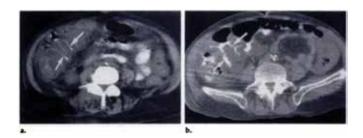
CT of Pseudomembranous colitis Marked thickening of the right side of the colon with tracking of contrast material (arrows) between the thickened folds. Thickening of pericolonic tissues is perceived. (b) Extensive inflammation of the right side of the colon with layers of contrast material between inflamed muccus folds (arrows). (FISHMAN, 1991)¹⁹.
